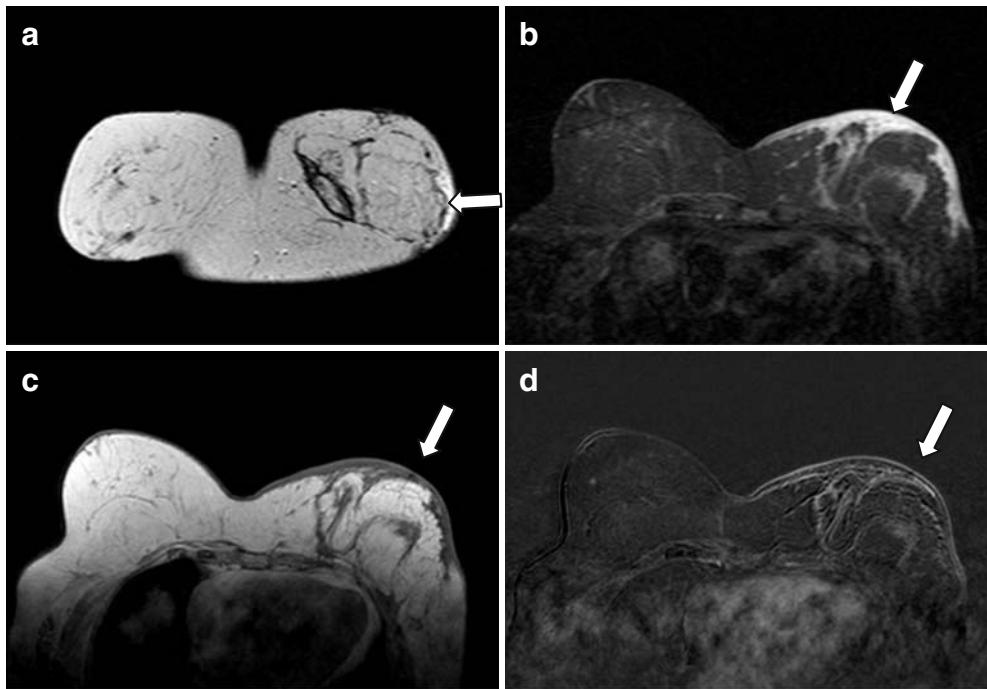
Case number 8735 of March 26th, 2009; 77 year-old patient, left skin sparing with *latissimus dorsi* flap and implant reconstruction in November 2008; T2-weighted sequences in coronal plan (A), T2-weighted sequence with fat saturation (B), dynamic study before the Gadolinium injection (C) and subtraction (D) in the transverse plans showing the edema (white arrows in A, B and C) and the low intensity enhancement due to the recent surgery (white arrow D).
